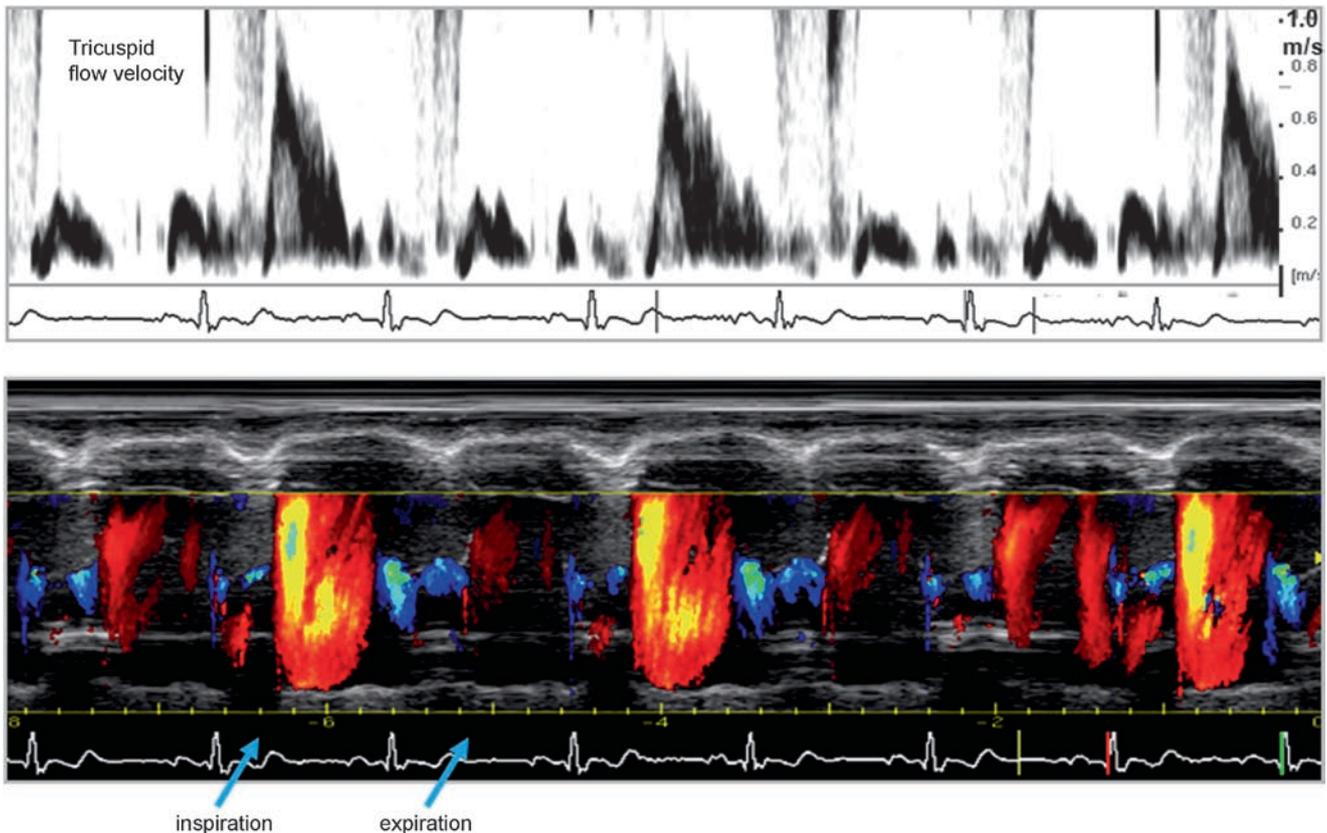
Tricuspid Doppler flow and colour M-mode of the right ventricle in a patient with constrictive pericarditis. Flow in the right ventricle is very fast and limited to early diastole; also notice the large variation with respiration
